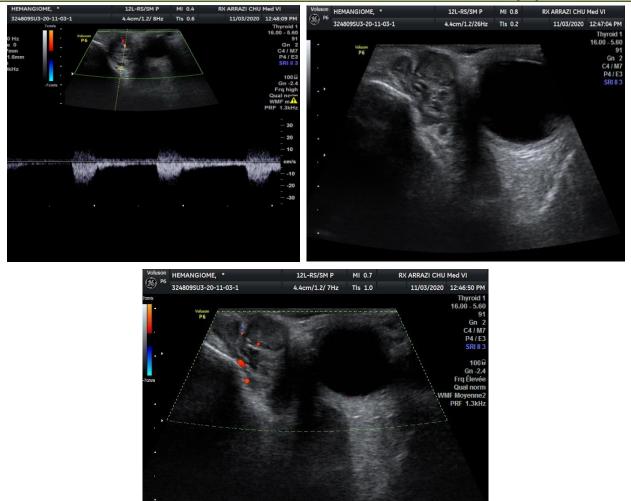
Heterogeneous hypoechoic intra and extra conical orbital lesion formation vascularized by color Doppler with a low resistance arterial flow
